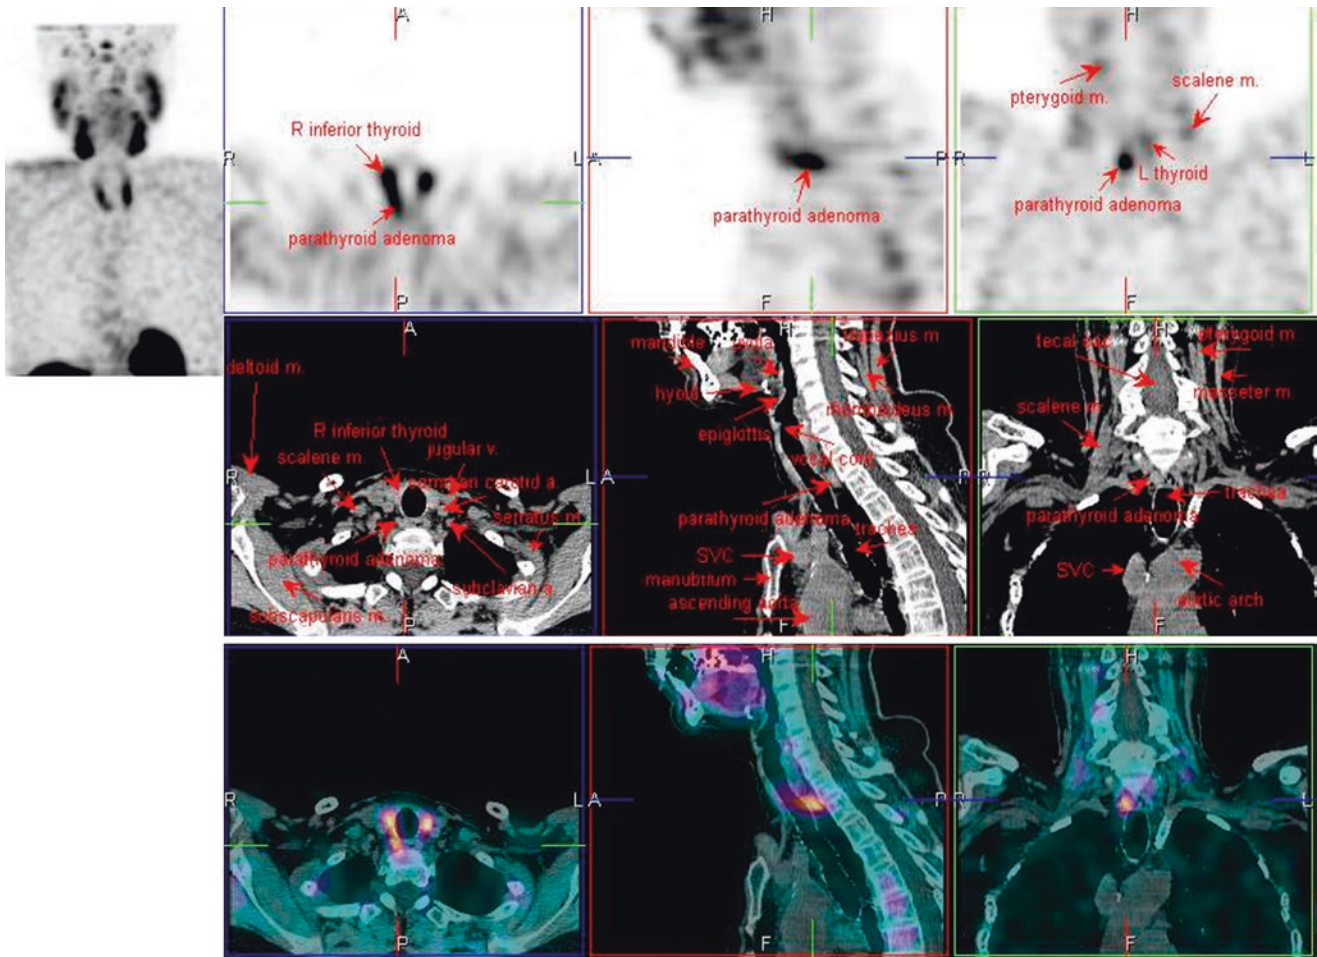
^{99m}Tc-MIBI SPECT/CT
